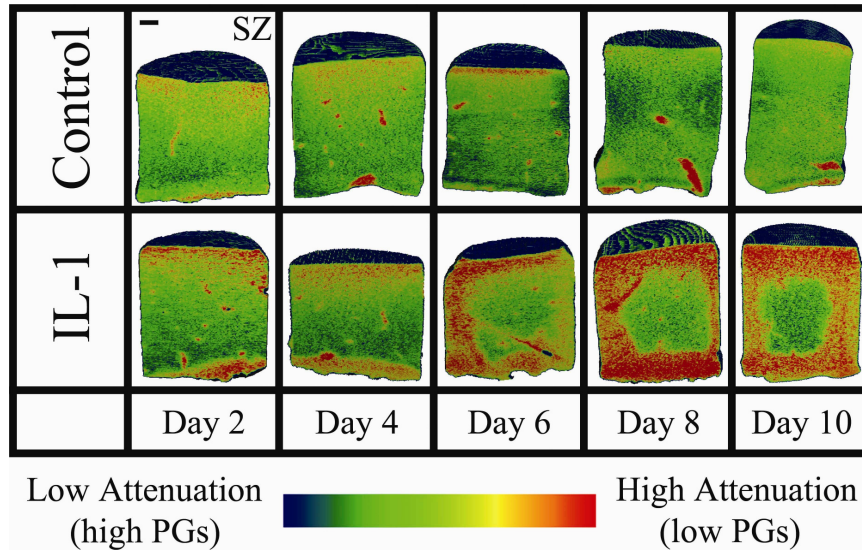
Representative 3D EPIC- μ CT images of control and IL-1-stimulated explants at 2-day intervals demonstrate progressive increases in attenuation in IL-1-stimulated samples. SZ denotes superficial zone (scale bar=1mm).
